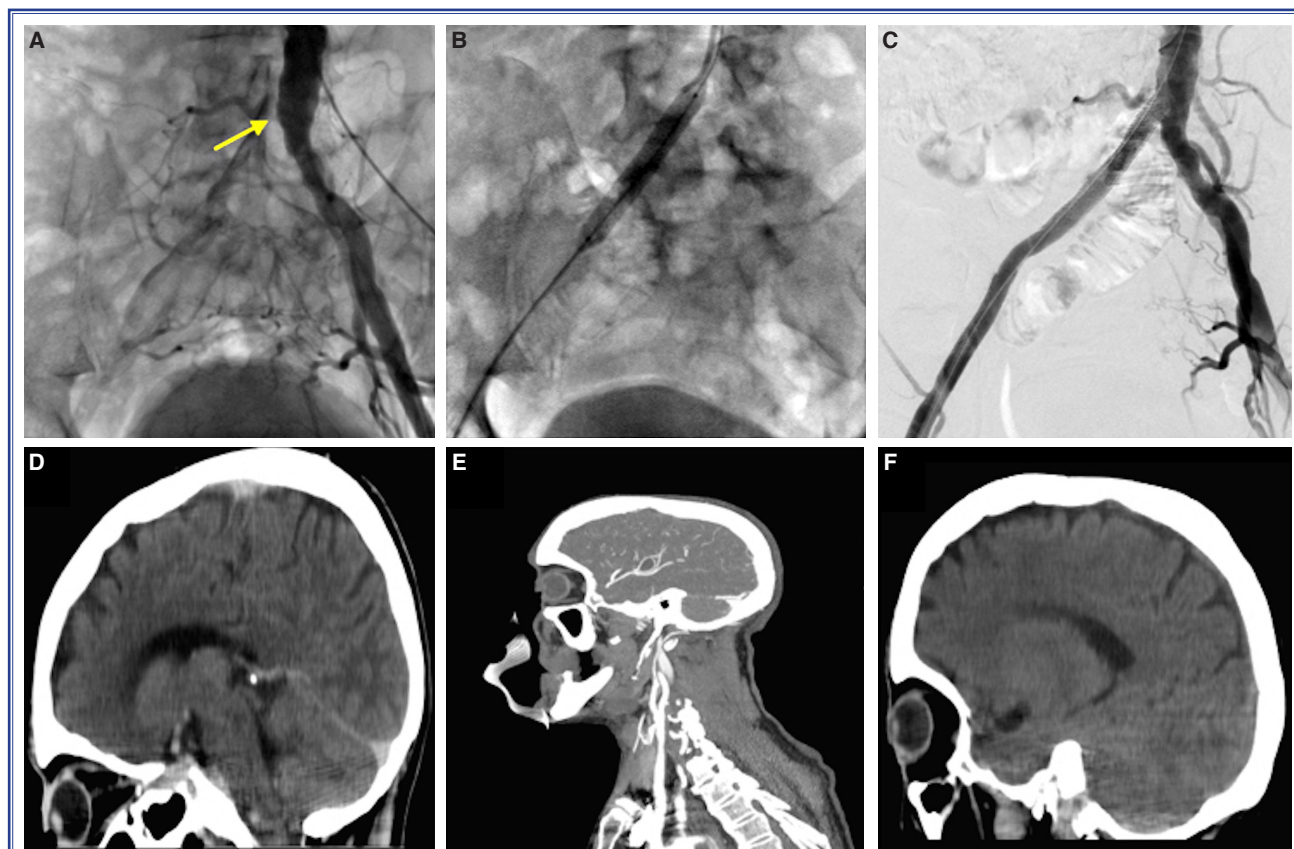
(A) Lower extremity angiography showed total occlusion in the proximal portion of the right common iliac artery. (B, C) A 9.0x57-mm stent was inserted in the vessel with the lesion following dilation of a 7.0x150 mm balloon. (D) Cerebral computed tomography scan revealed no sign of intracerebral hemorrhage. (E) Carotid and vertebral computed tomography showed no ischemic lesion. (F) Cerebral computed tomography image taken after 48 hours indicated normal findings.
